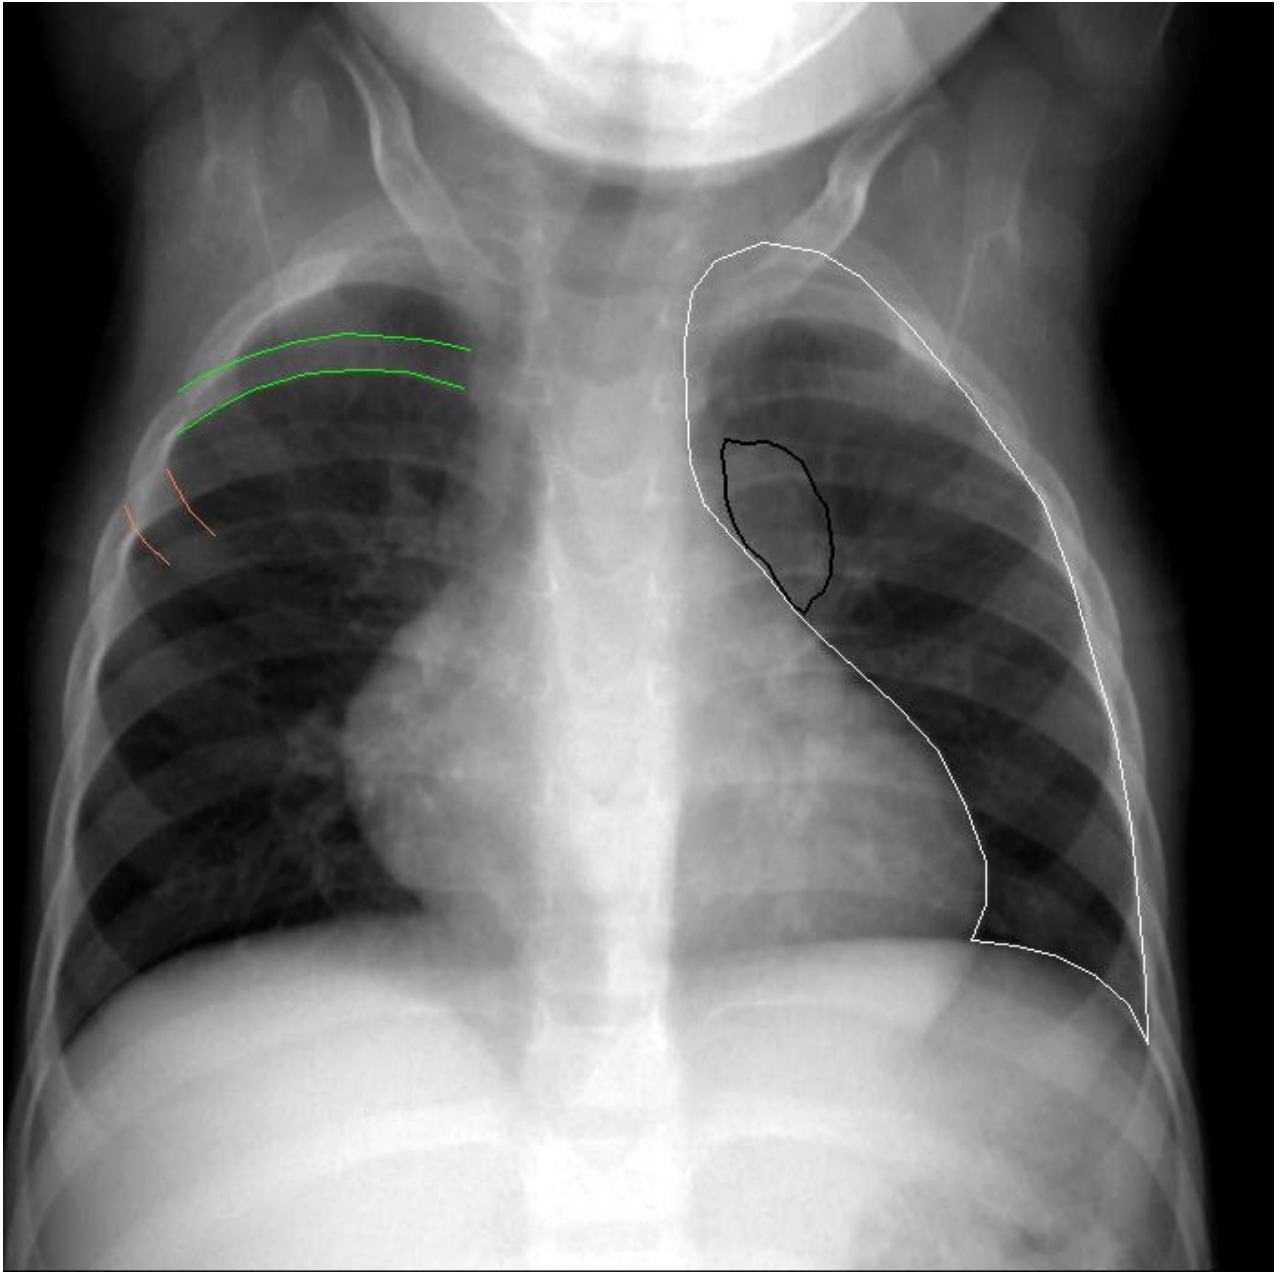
Structures of interest in a chest X-ray. The green outline shows the posterior 3rd rib on the right side of the patient. The part of the rib outlined in orange is the anterior portion of the 3rd rib. The lateral portion can be considered the part of the rib between these two sections. This is a typical representation of the lateral rib. The left lung is outlined in white. The first rib can be seen crossing the clavicles just above the visible lung while ribs 2-8 visibly overlap the lungs. Rib 8 is barely visible. The rest of the ribs lie below the diaphragm. This image also shows an abnormality in the left lung outlined in black.
